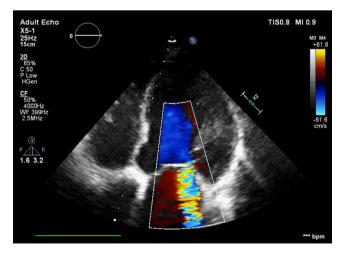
Transthoracic Doppler echocardiography showing severe mitral regurgitation.
